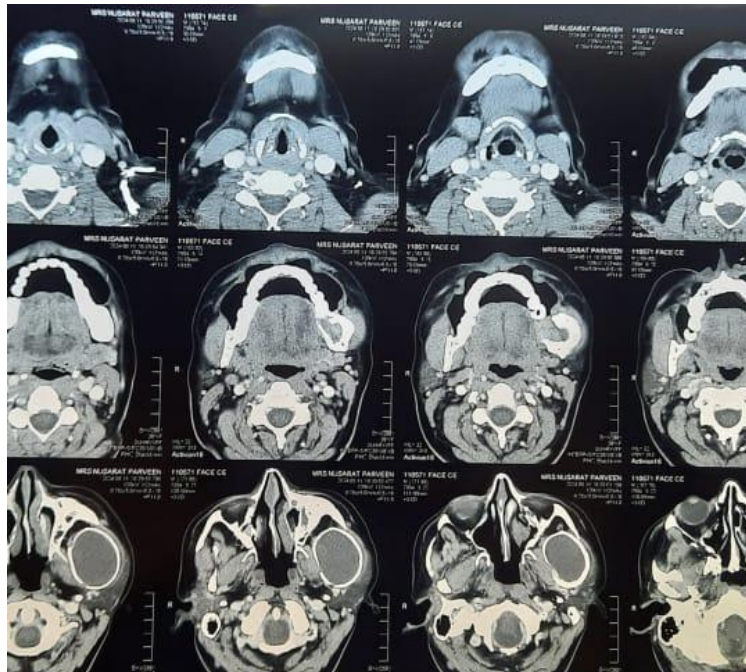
Axial view of CT showing extension of cyst
